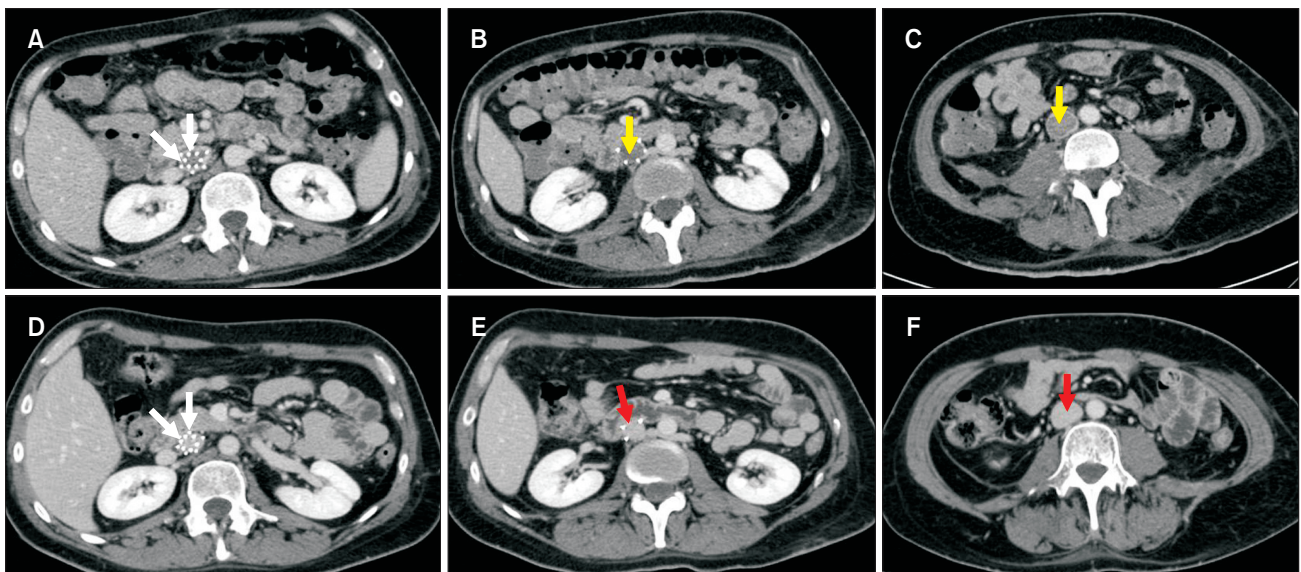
(A-C) Computed tomography (CT) axial images taken in November 2020 showed inferior vena cava (IVC) filter (white arrows) and IVC thrombosis (yellow arrows). (D-F) CT images performed in January 2021 showed completely resolved IVC thrombosis (red arrows) and IVC filter (white arrow).
